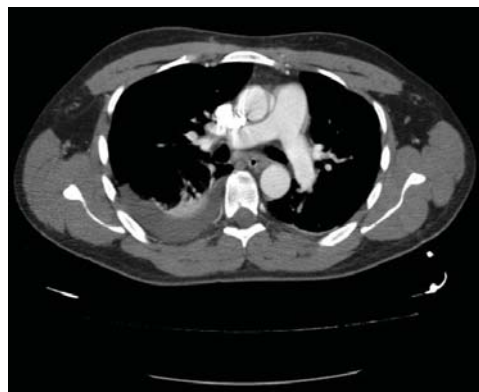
Right pleural effusion in thorax axial CT.
